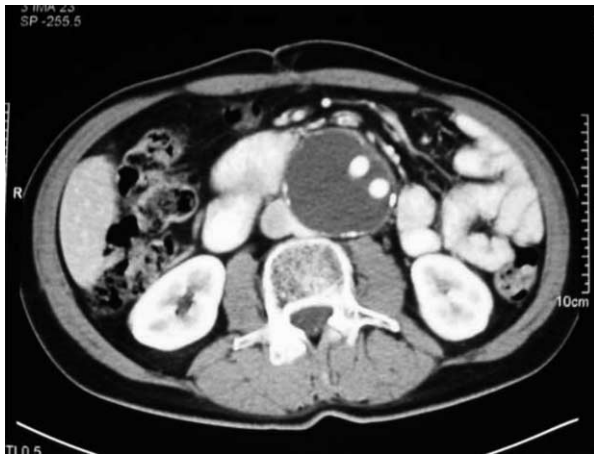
Computed tomography scan demonstrates recurrent aortic sac seroma.
